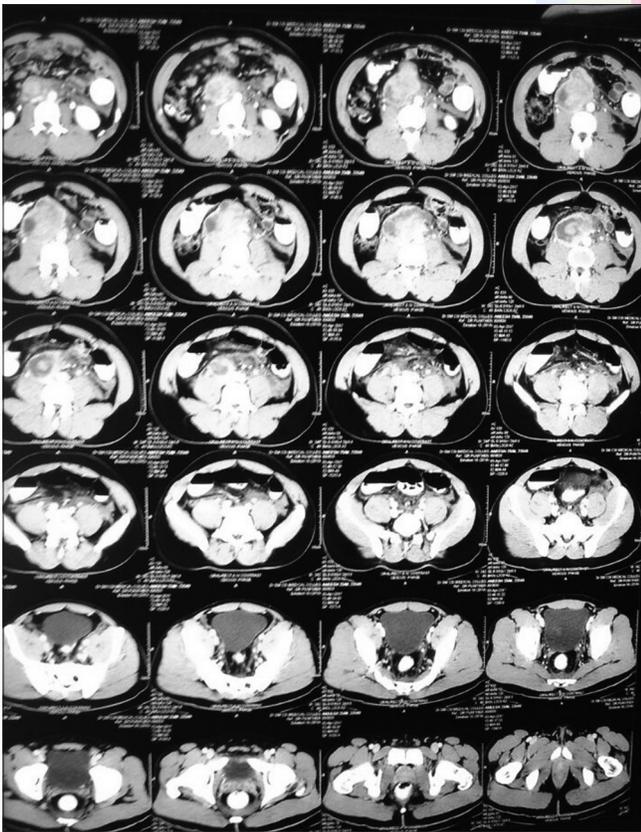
Computed tomography abdomen
